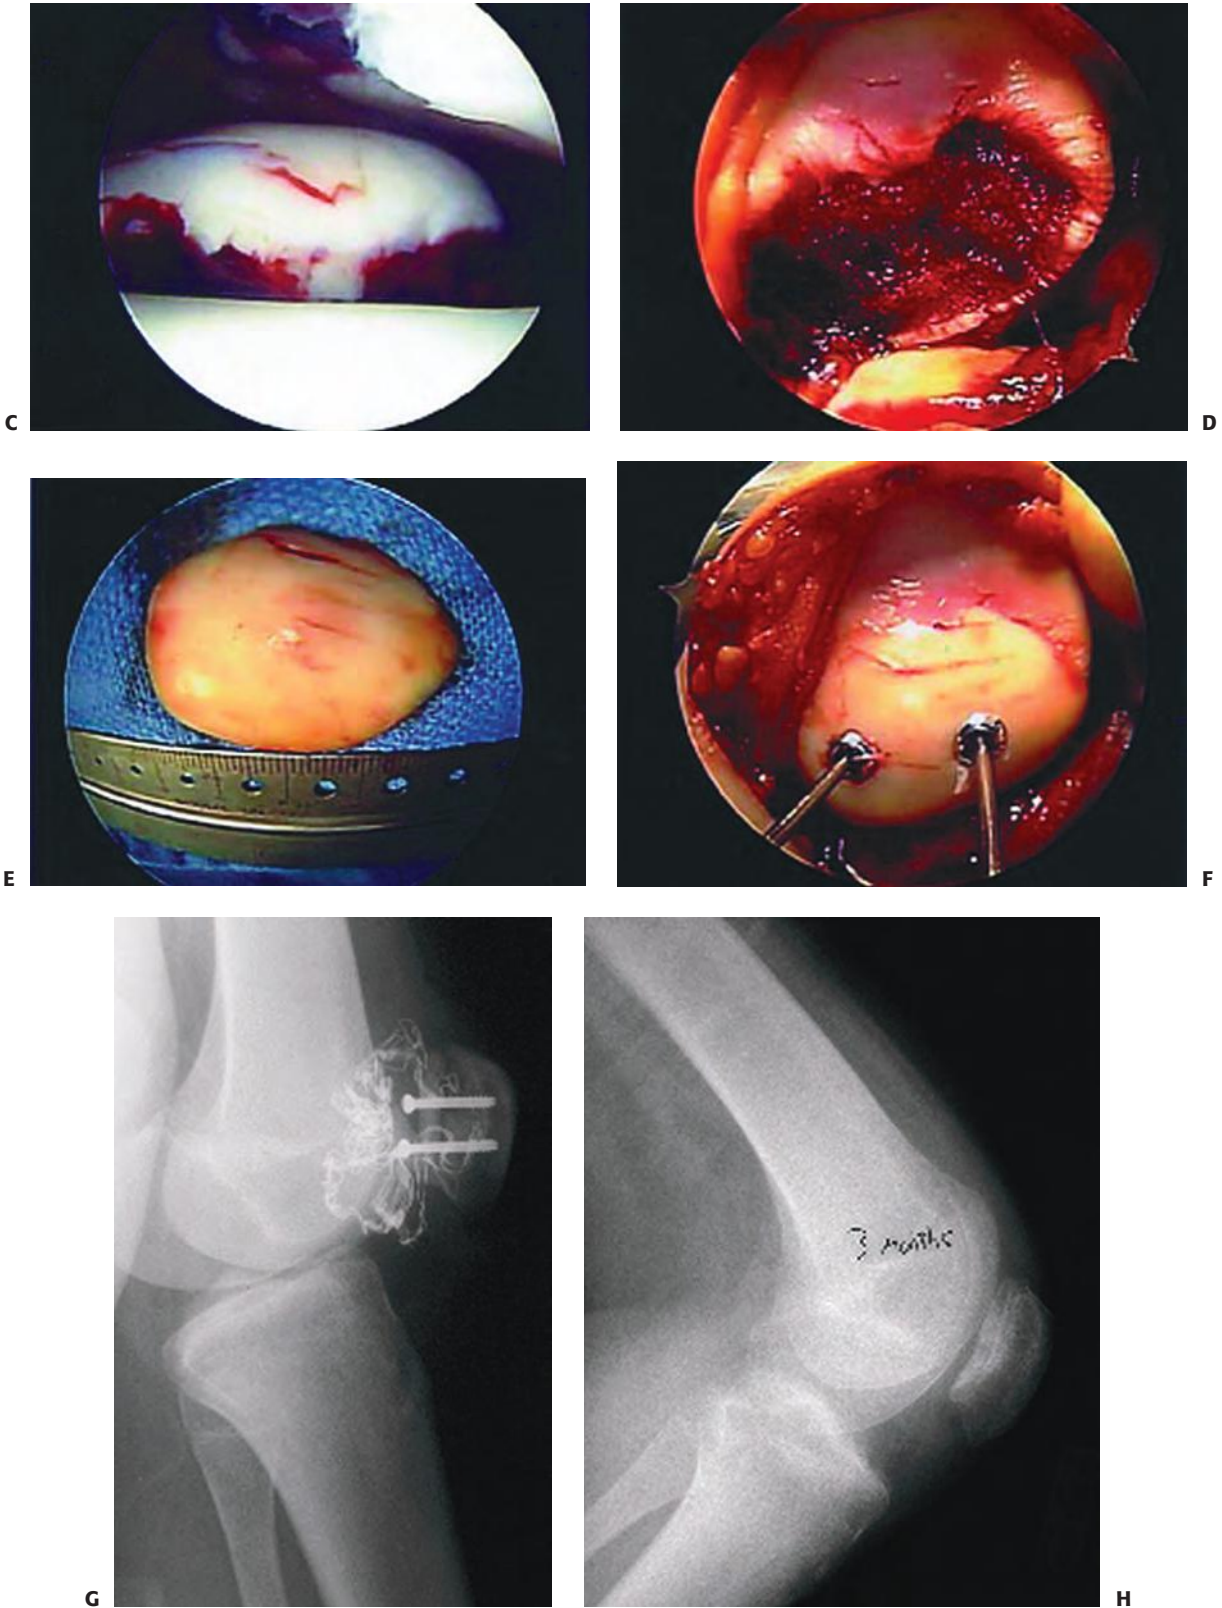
(continued) C: Arthroscopic view of osteochondral fragment in the lateral recess. D: Open view of patella. E: Open view of osteochondral fragment. F: Open view of reduction and cannulated screw fixation of medial patellar facet. G: Intraoperative lateral radiograph after fracture fixation. H: Lateral radiograph 3 months after fracture fixation and 6 weeks after screw removal demonstrating healing.
